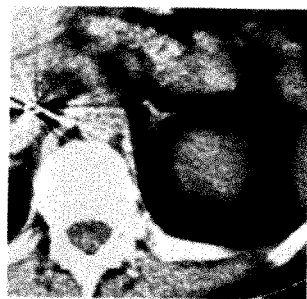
CT scan of 55-year-old man with suspected carcinoma of pancreas. Pancreas normal, but triangular normal left adrenal gland found anterior to upper pole of left kidney.
